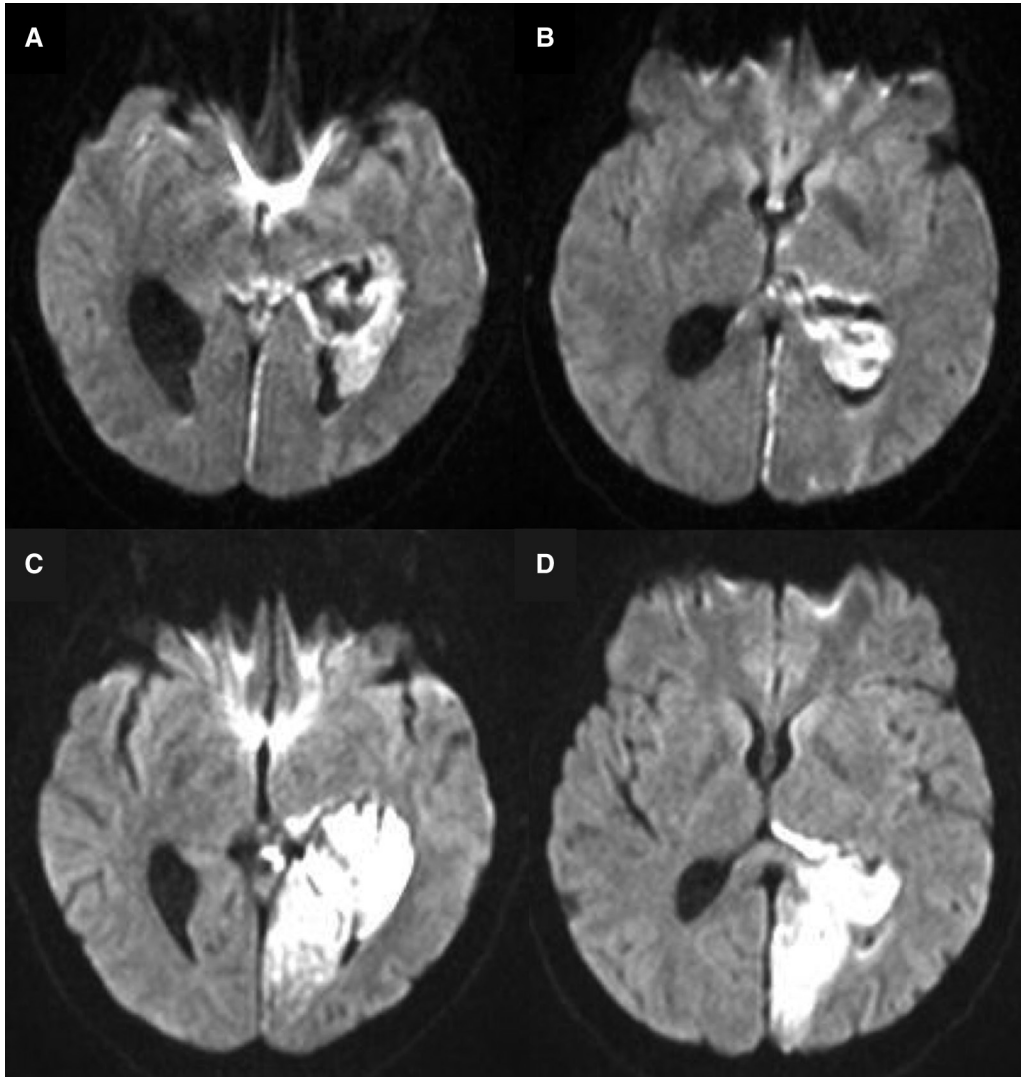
Pre- and post-procedure diffusion-weighted images (DWI). (A and B) Preoperative DWI on day 0 shows hyperintensity around the choroidal fissure, including the hippocampus. (C and D) DWI on postoperative day 2 shows new ischemic lesions in the occipital and medial temporal lobes.
